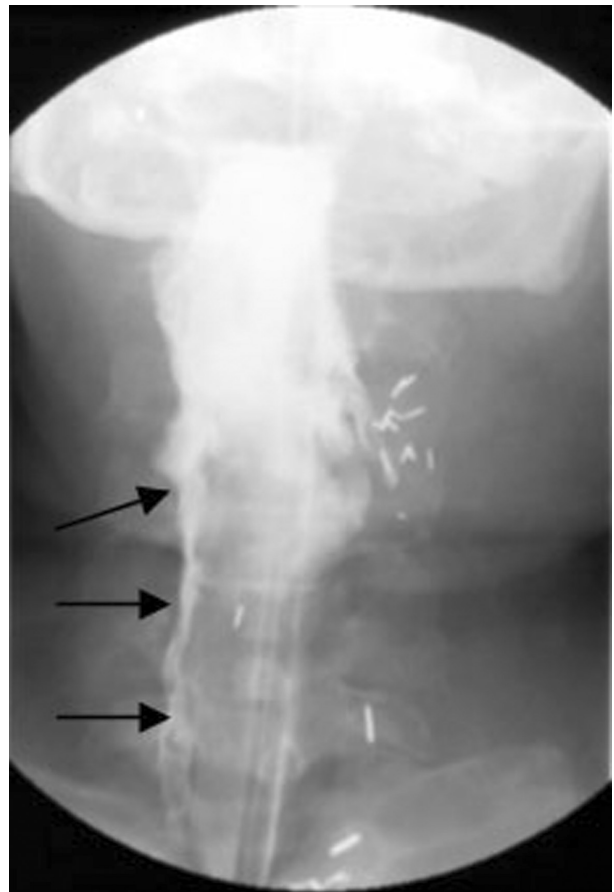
A 54-year-old man, with a right T4N0M0 piriform sinus carcinoma. A total pharyngolaryngectomy was performed. The hypopharyngeal defect was reconstructed using a tubed radial forearm flap. Nine days postoperatively a fistula was noted during patient care. Fourteen days postoperatively the first routine postoperative RSS was performed (grade 5, see Fig. 1f). Nasogastric tube feeding and local wound care were continued. The initial follow-up radiographic swallowing study 1 week later showing a persistent grade 2 extravasation on the right side. The grade 4 extravasation in the left neck has resolved. After 12 days a second follow-up RSS was performed. All the leakages have resolved (grade 0, see Fig. 1a). The resolution time was 19 days.
